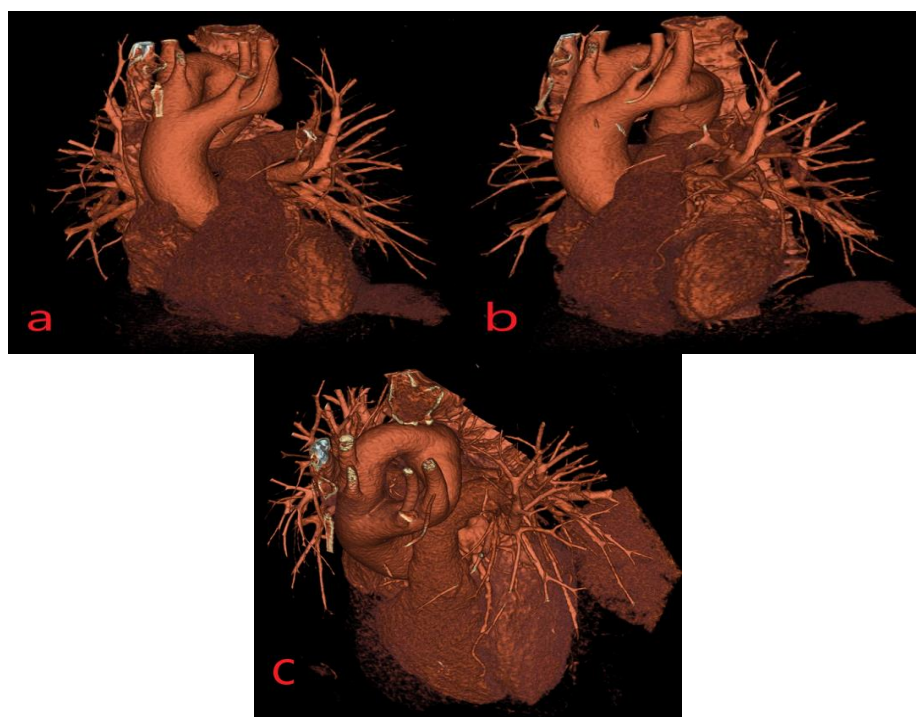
Three-dimensional volume-rendered CTA depicting right-dominant double aortic arch forming a complete vascular ring, a), b) and c).
